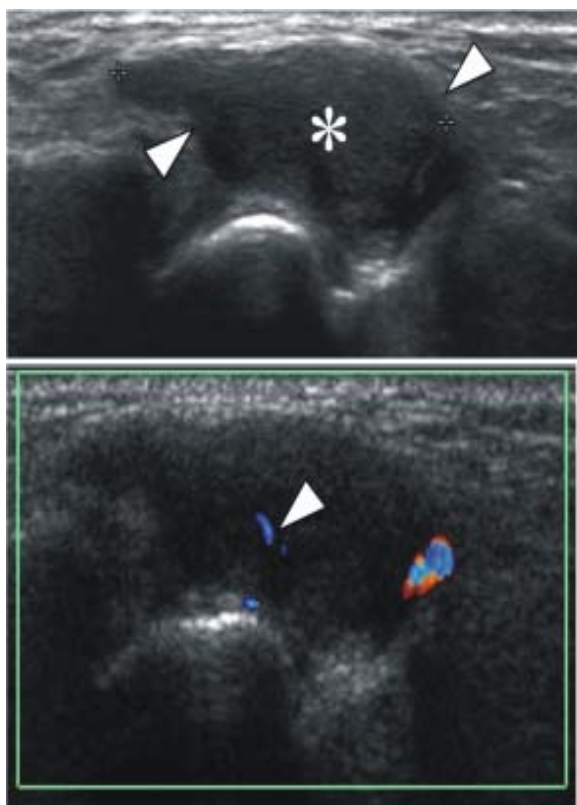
The patient is a 33 year-old woman with a giant cell tumor of the tendon sheath (GCTTS) of the wrist. Sagittal (A) and sagittal color Doppler (B) sonograms obtained over the radial aspect of the wrist show a solid, heterogeneous hypoechoic mass (asterisk) with well-defined borders (arrowheads). In B, note sparse internal flow signals (arrowhead).
